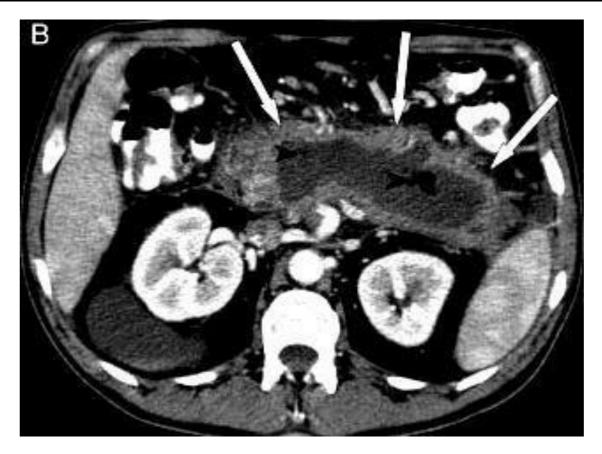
CT image of walled-off necrosis
